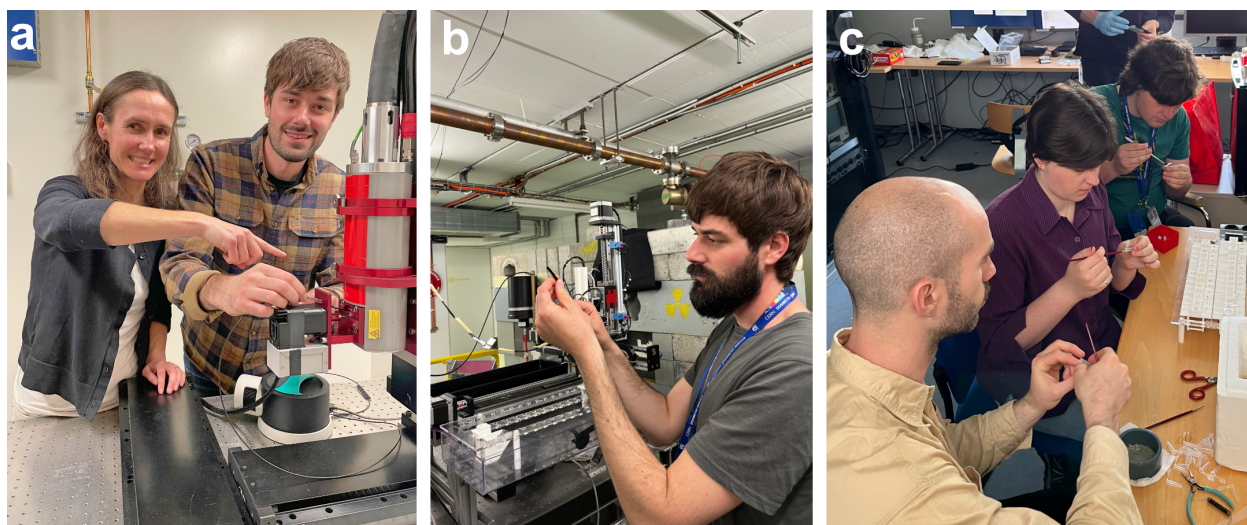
The author and his supervisor using PSDs to measure dose from kilovoltage x-rays (a), and VHEE (b). Collaborators immobilizing *Drosophila* larvae for irradiations (c).
